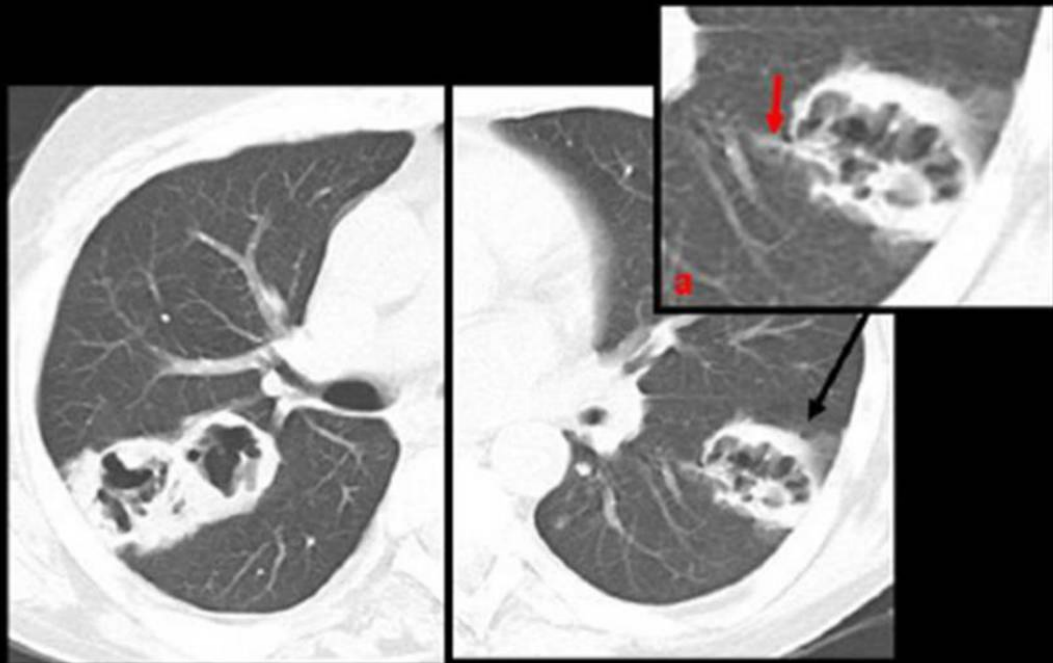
Another case of septic emboli. HRCT again shows multiple cavitating, nodular lung lesions. Note *feeding vessel sign* (a).
